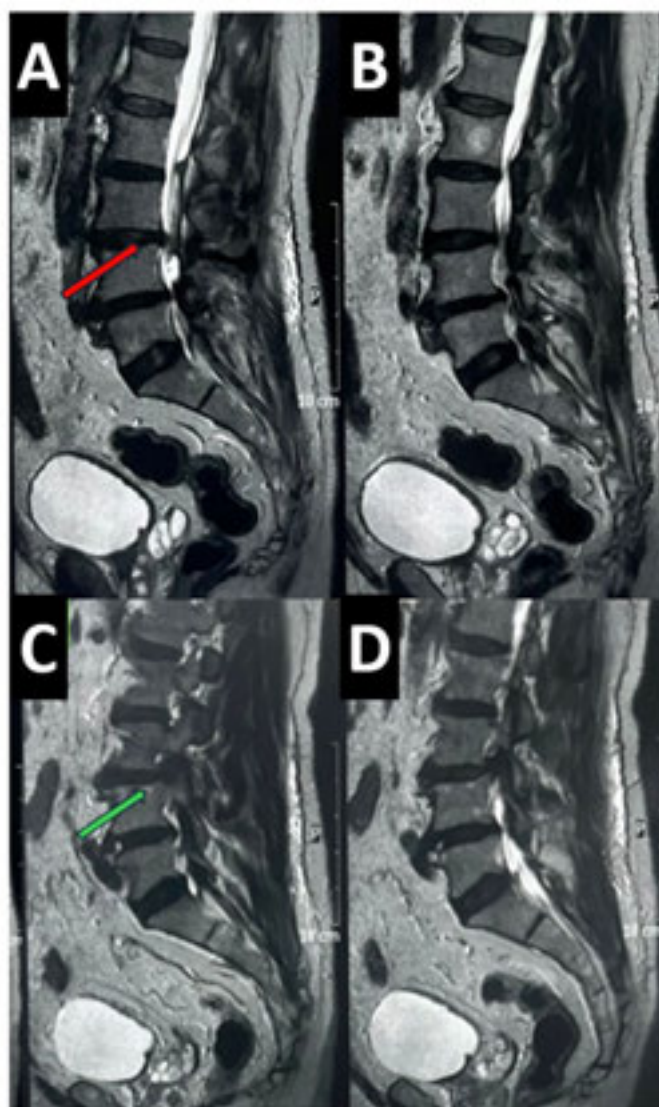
T2-weighted magnetic resonance imaging of the lumbosacral spine, showing median sagittal (A and B) and left paramedian (C and D) sections. The red arrow points to herniation of the L3-L4 disc (A) and the green arrow highlights foraminal stenosis in L3 and L4 on the left (C).
